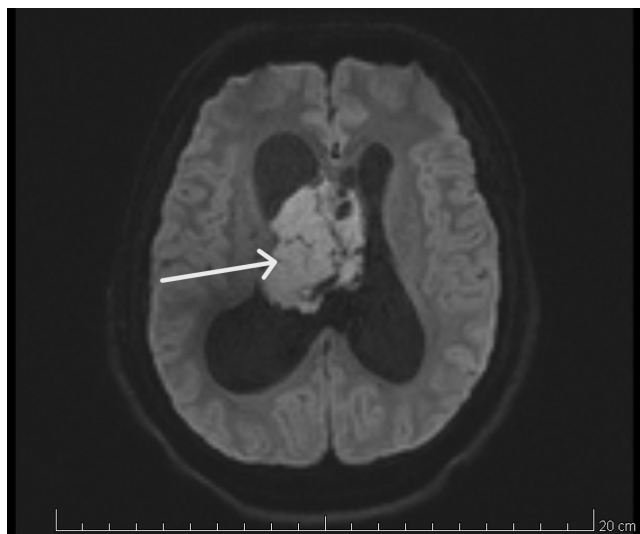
Magnetic resonance imaging (MRI)-contrast enhanced of brain (diffusion-weighted imaging) shows a large heterogeneous mass with both solid and cystic components in the right lateral ventricle near the foramen of Monro, resulting in significant dilatation of both lateral ventricles with a mass effect.
